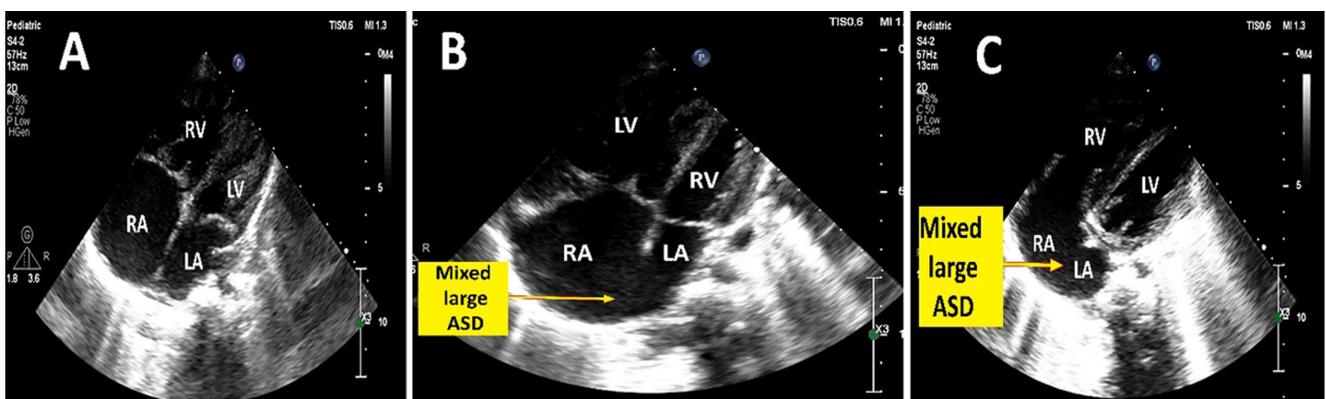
Figures A, B, and C demonstrate the importance of sweeping from the anterior (A) to the posterior (C) to accurately delineate the anatomy of the atrial septal defect using two-dimensional echocardiography. This approach reveals a notable variation in the size of the defect, which increases from the anterior to the posterior. It particularly highlights the near absence of a significant portion of the septum in the posterior plane at the level of the coronary sinus.
